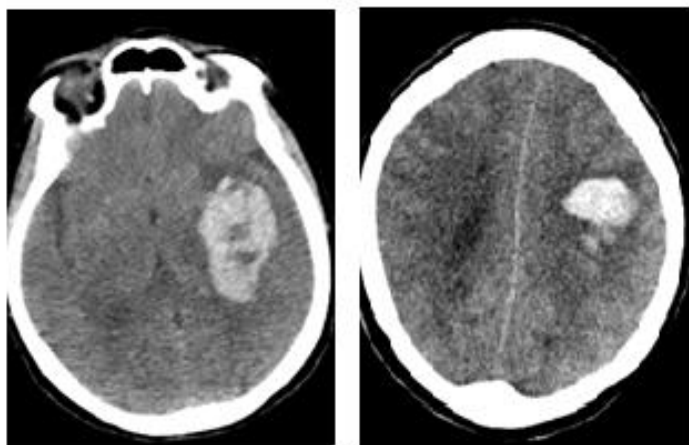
CT imaging on first arrival to the emergency department. Heterogeneous intracerebral haemorrhage area with oedematous hypodensity in the left temporoparietofrontal area and periphery, causing 11 mm right shift
